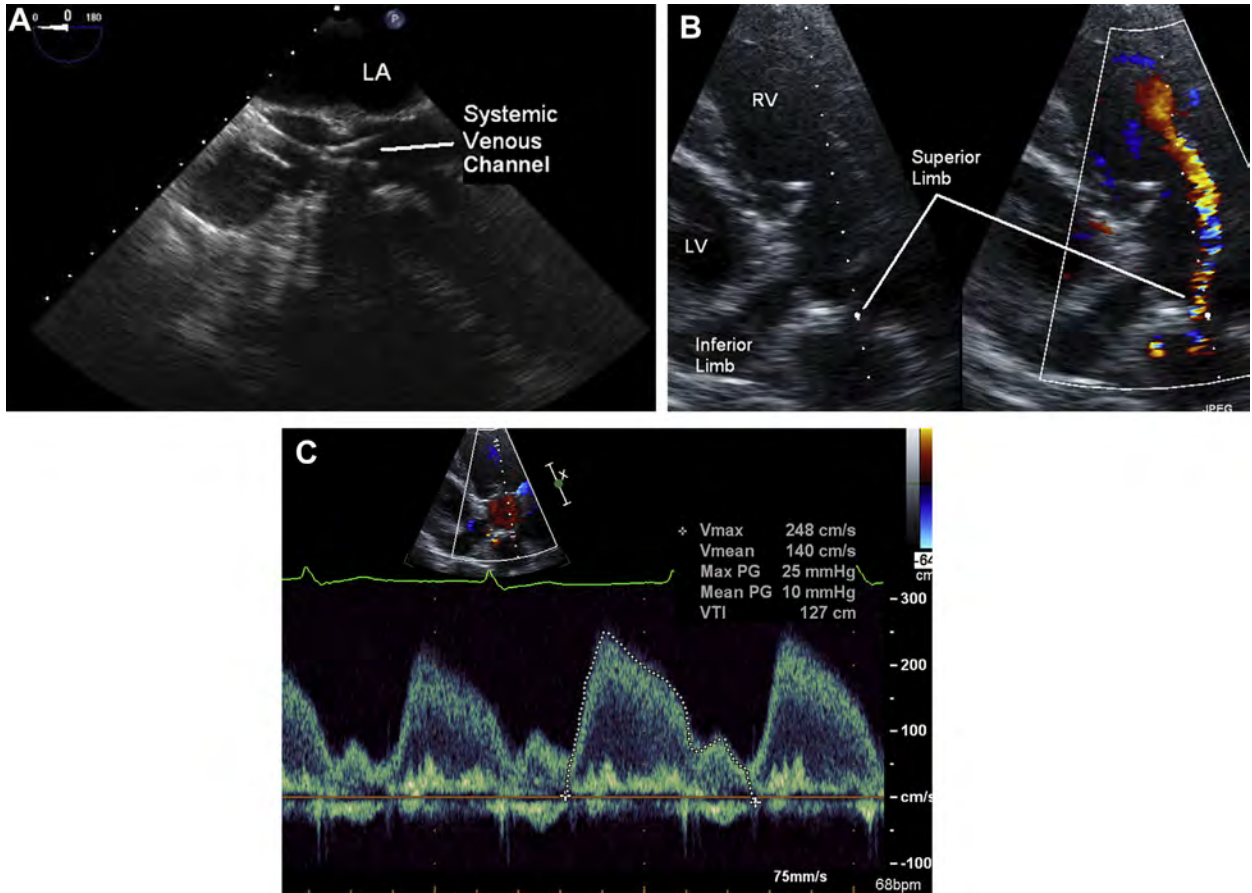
(A) TEE in four-chamber view high in esophagus (at 0°) demonstrates the superior limb of the systemic venous channel with two pacing wires seen within the channel. (B) Transthoracic image in off-axis parasternal view using color Doppler demonstrates significant narrowing of the superior limb of the systemic venous channel. The inferior limb is seen as well. (C) Spectral Doppler of the superior limb of the systemic venous channel demonstrates that the flow does not return to baseline and there is a mean gradient of 10 mm Hg. LV, Left ventricle; RV, right ventricle.
